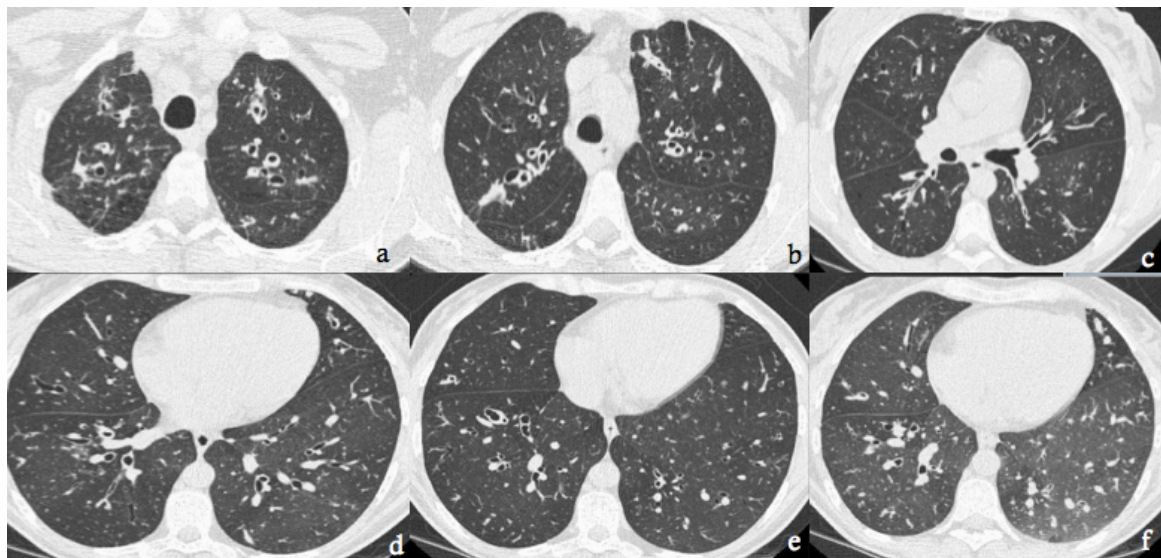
Low-dose axial CT images acquired in a 21-year-old male patient with cystic fibrosis at 12-months of treatment with Ivacaftor using the 7-section LD ASIR protocol (effective dose 0.1mSv). Images were obtained at the level of the lung apices (a), aortopulmonary window (b), carina (c), and at the widest cardiac (d) and thoracic (e) diameters. Expiration phase images were obtained at the level of the aortopulmonary window (not shown) and at the widest cardiac diameter (f).
